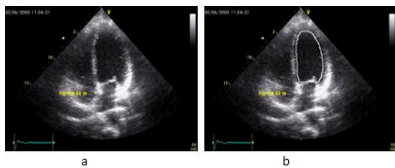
Echocardiogram image (a) and user defined contour (b)
